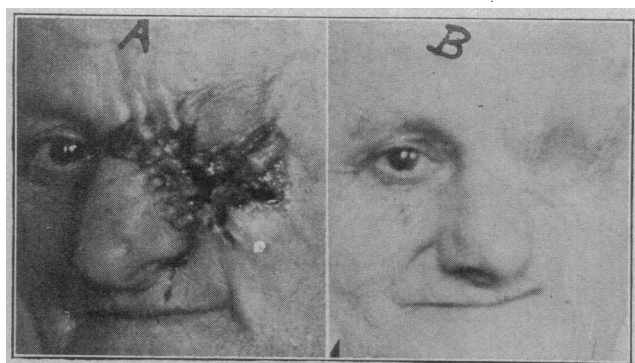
A, epithelioma involving nose, cheek, brow, eyelid, globe, and bones of orbit and antrum in a woman, aged 59, referred by Dr. T. L. Bradford of Philadelphia. Roentgen treatment had previously been used unsuccessfully. One intensive electrothermic coagulation treatment under ether anesthesia was given in March, 1917. B, result of one treatment. No recurrence in year and a half.
